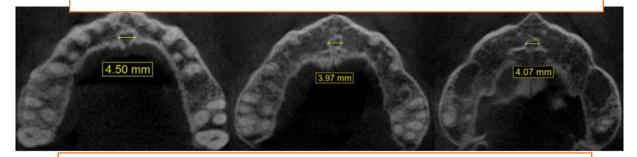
Axial CBCT images revealed Medio-lateral diameters (M-L) of NPC
